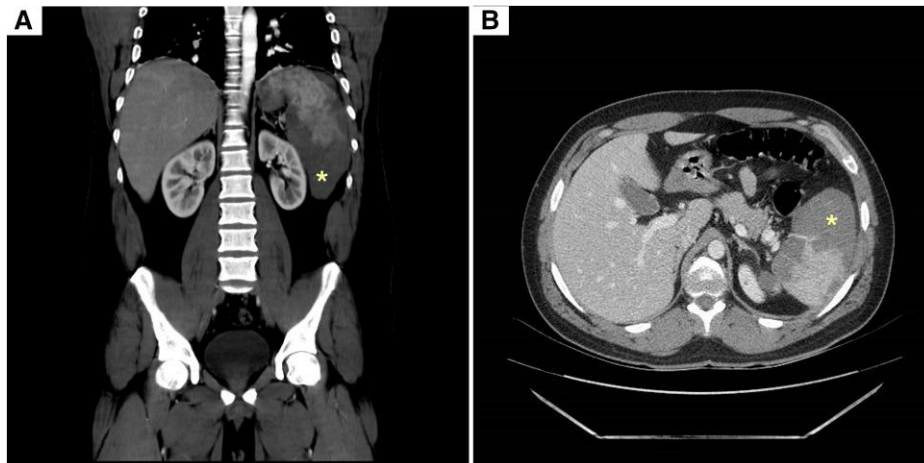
Contrast-enhanced computed tomography images revealing wedge-shaped, hypodense areas in the spleen (*). (A) Coronal scan. (B) Transversal scan.
